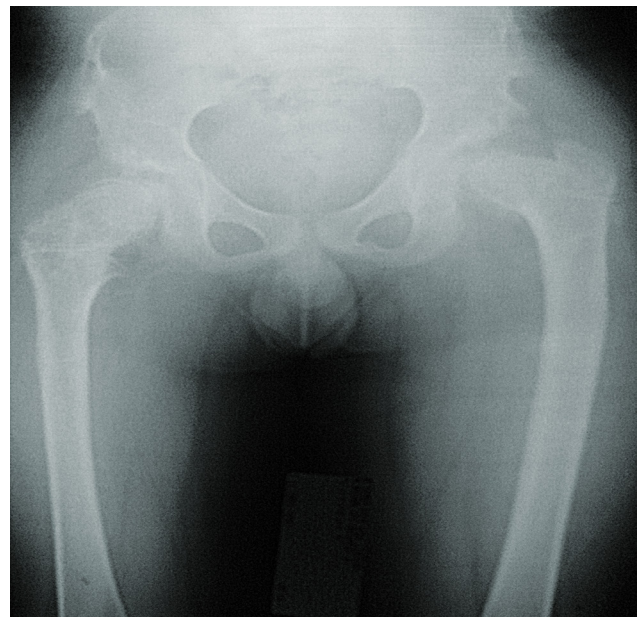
Anteroposterior radiograph of the pelvis at the 6th year final follow-up.
